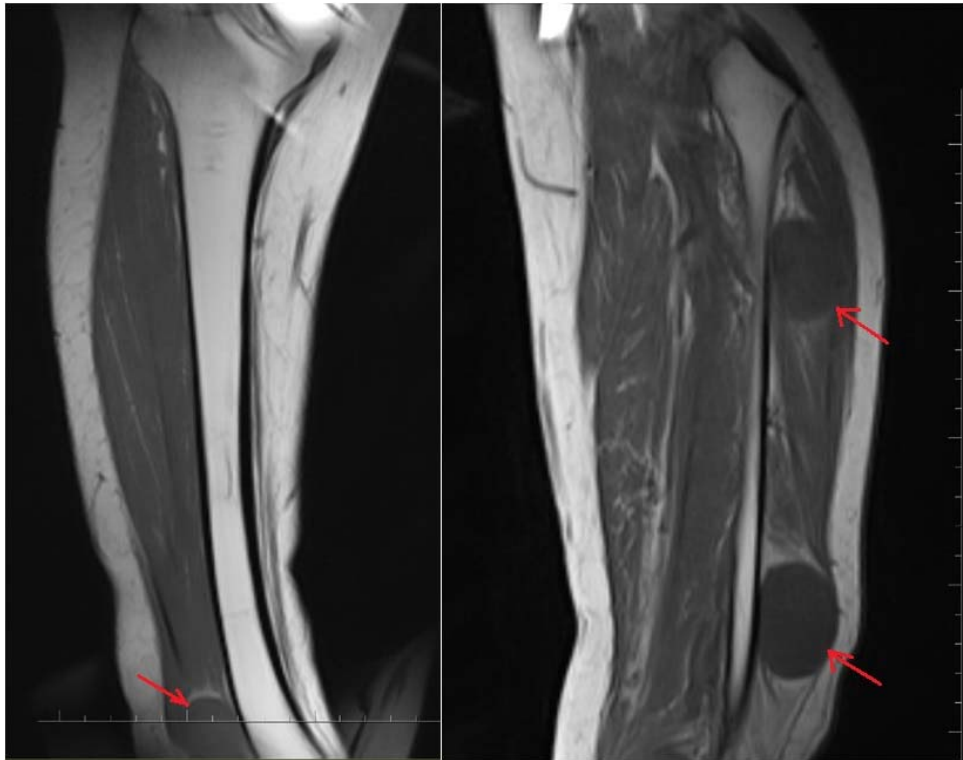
In MRI, in both crurises, hypointense in T1 and T2 sequences, in well-limited soft tissue masses in peroneal nerve course.
